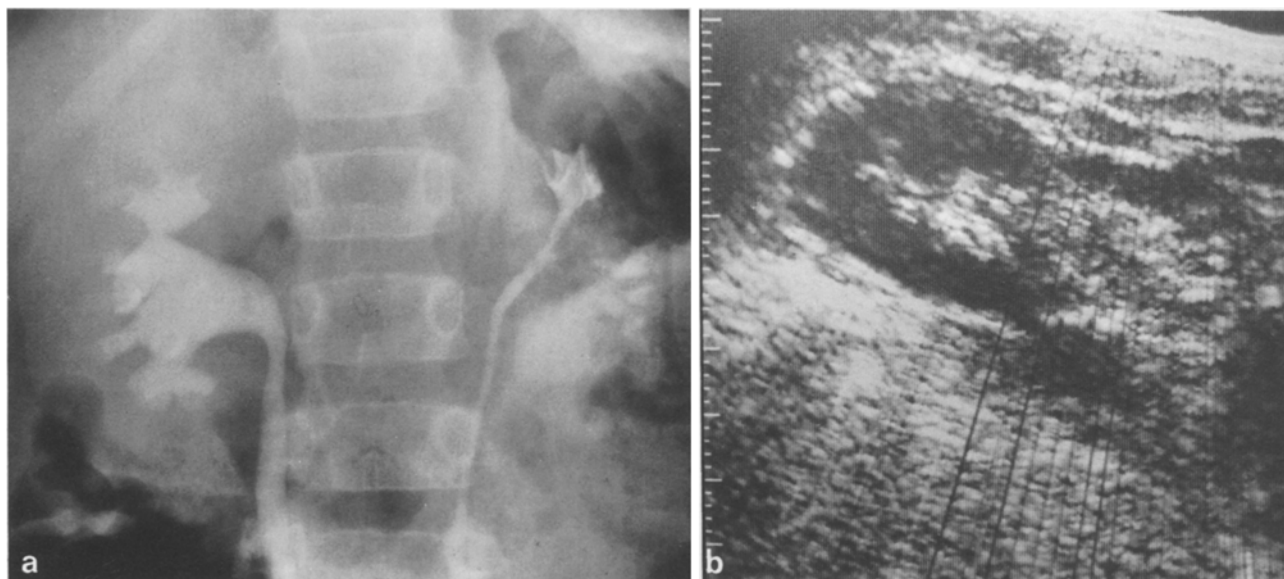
a, b. Patient 5. Complete duplication with normal sinus. a Excretion urogram showing left sided duplication. b Coronal sonogram of left kidney with normal sinus echo complex. All other views demonstrated a single central sinus echo complex
